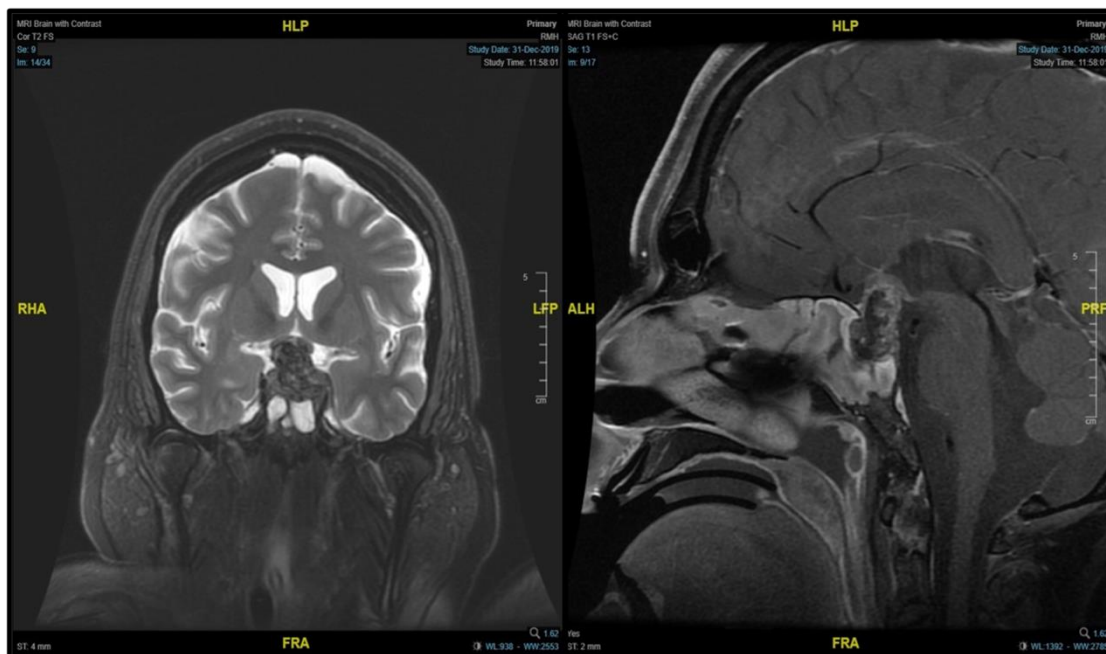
A: MRI brain with contrast showing sellar lesion with suprasellar extension and extension inferiorly to the sphenoid sinus. B: Post gadolinium study showed the lesion to be enhancing in its periphery only with mild heterogeneous enhancement in the center
